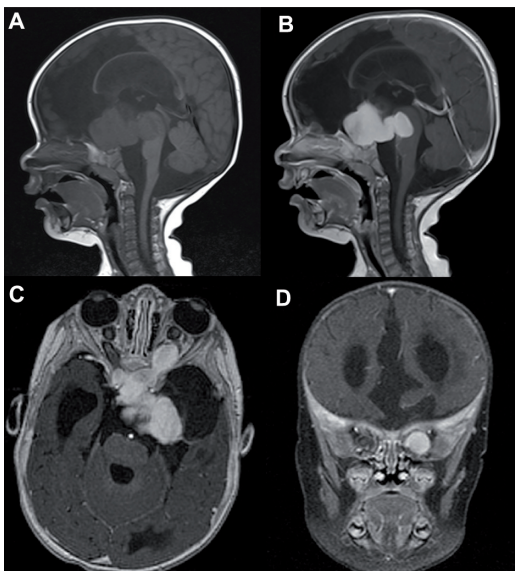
Five-month-old male with an optic pathway glioma (Case 14). Sagittal T1-weighted images pre- (A) and post-gadobutrol (B) show an enhancing suprasellar mass that has enlarged and infiltrated the optic chiasm. Posterior extension of the mass has a mass effect on the brainstem. Transverse (C) and coronal (D) T1-weighted imaging post-gadobutrol administration shows extension of the glioma into the left optic nerve with intense homogeneous enhancement.
